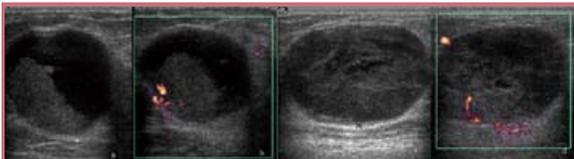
two examples of intracystic papillary tumours. a, apparent fluid-debris level, b, haemorrhagic cyst content. b&d, Power Doppler depicts vascularity of solid components.
